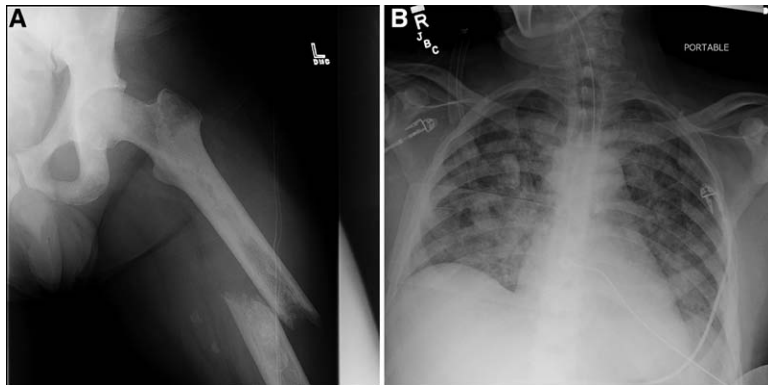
Initial imaging. X-ray of the left lower extremity demonstrating a closed, oblique fracture of the left femur with displacement of the distal femoral fragment (A). Chest X-ray obtained shortly after endotracheal intubation showing bilateral patchy infiltrates consistent with acute respiratory distress syndrome (ARDS; B).
